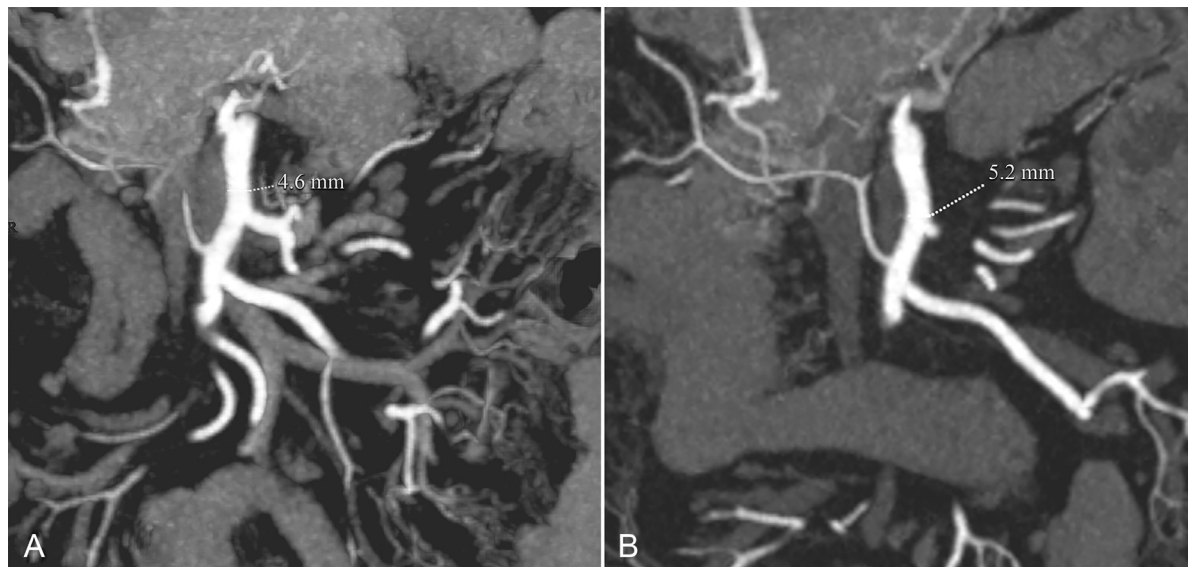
Computed tomography scans post-discharge (A) at 1 year, the diameter of true lumen was 4.6 mm and (B) at 1.5 year, the diameter of true lumen was 5.2 mm. At both points, the distal branches of the superior mesenteric artery were patent.
